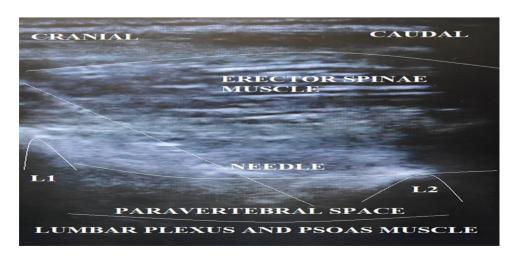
Ultrasound image of PVB showing needle, L1 and L2 vertebrae, and paravertebral space.
